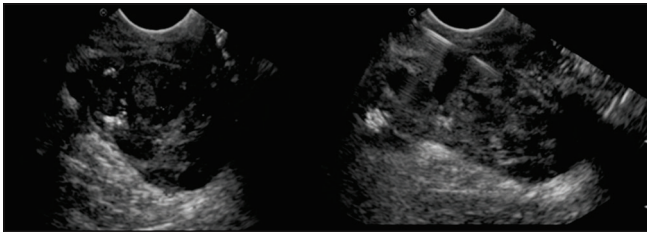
Endoscopic ultrasound image showing 5.1 cm × 2.2 cm heteroechoic mass with solid and cystic areas till 7 cm starting from anal verge and transanal fine-needle aspiration biopsy using a 22-gauge Wilson-Cook needle
